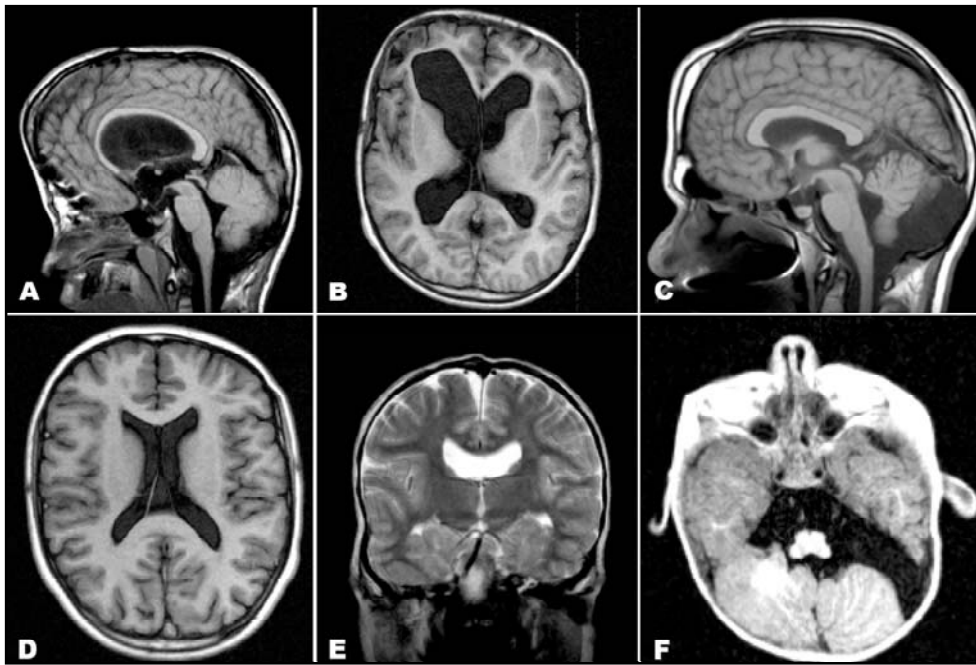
Ventriculomegaly and corpus callosum hypoplasia - MRI in sagittal plane and T1 acquisition (A) and axial plane and T1-IR acquisition (B). cavum Vergae and arachnoid cyst in the posterior fossa - MRI in sagittal plane and T1 acquisition (C) and axial plane and T1-IR acquisition (D). Septum pellucidum hypoplasia - MRI in coronal plane and T2 acquisition (E). Arachnoid cyst in the posterior fossa - MRI in axial plane and T1-IR acquisition (F).
